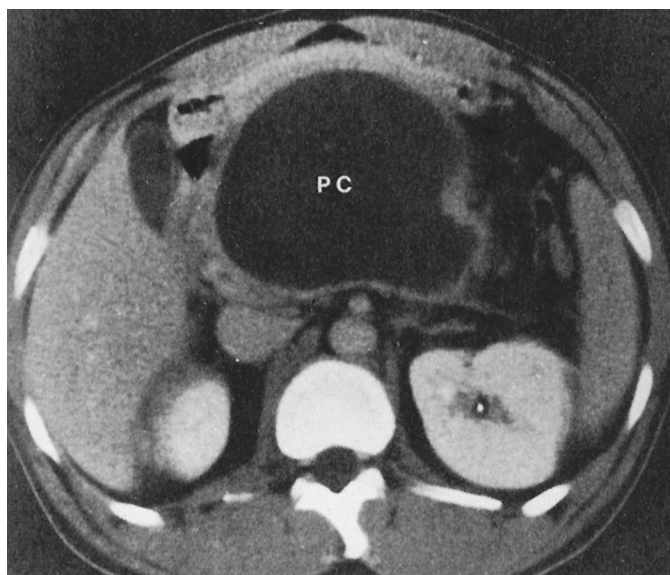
Pseudocyst. Follow-up computed tomographic scan (same patient as in Fig. 10.12) 5 months after the episode of acute pancreatitis demonstrates a large pseudocyst (PC). This large pseudocyst will probably not resolve spontaneously and may need drainage. (From Freeny P, Lawson T. In: Putman CE, Ravin CE, eds. *Textbook of Diagnostic Imaging*. Philadelphia: WB Saunders; 1988.)
